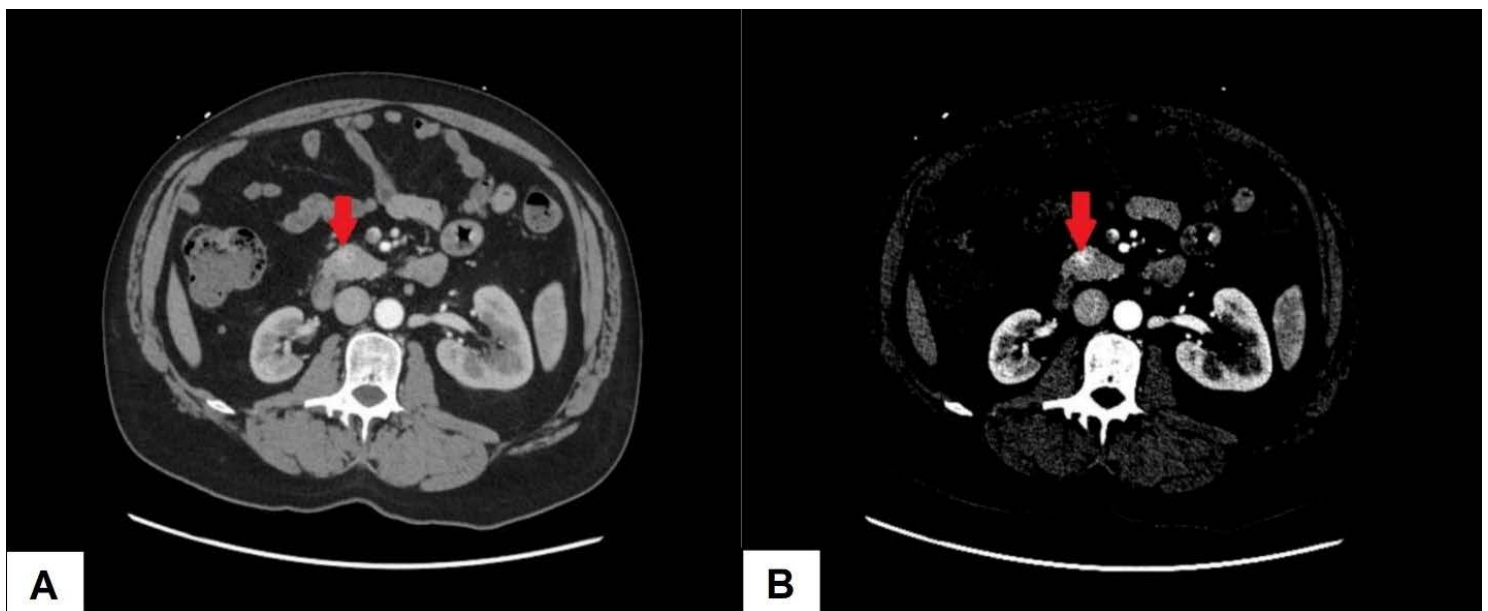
Contrast enhanced CT of the abdomen and pelvis demonstrating an enhancing lesion of the pancreatic head measuring approximately 1.4×1.3 cm, suspicious for a pancreatic neuroendocrine tumor. (A) Abdominal window. (B) Liver window.
